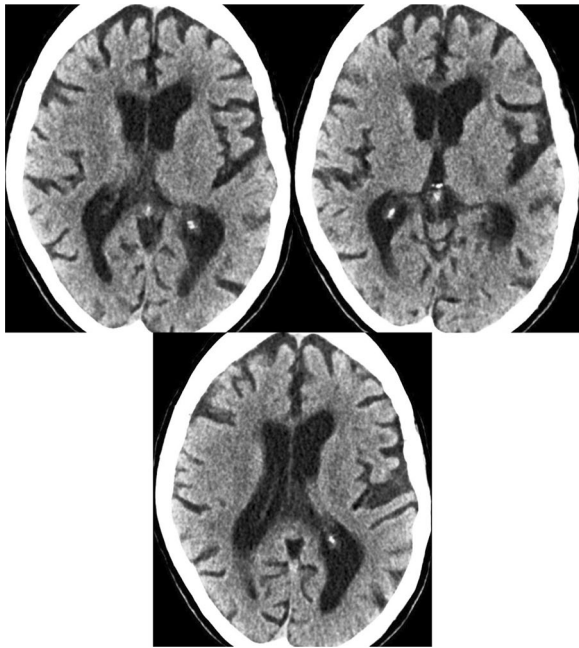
Second CT Findings (done within 24 h from complaint starting): showing no significant changes compared to the 1st CT with still no evidence of acute vascular insult
